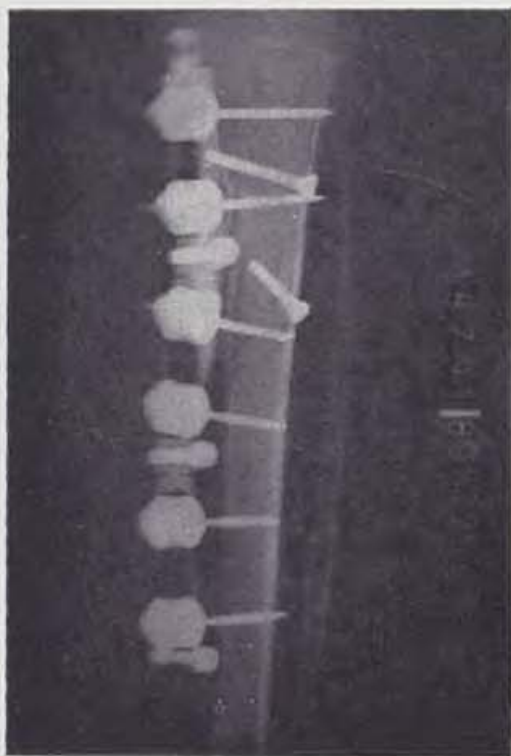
X-ray of the limb 10 days after injury. — Fig. 2. X-ray after soft tissue and bone necrectomy.
